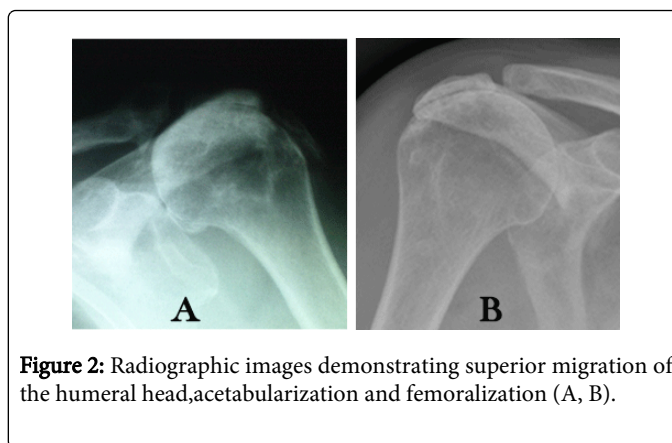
Radiographic images demonstrating superior migration of the humeral head, acetabularization and femoralization (A, B).
